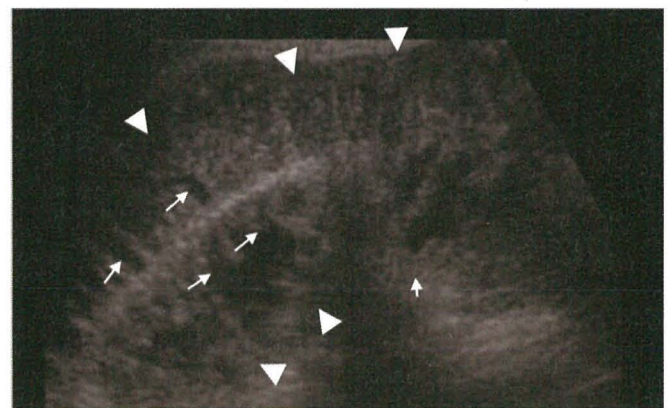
Ultrasound scan showing a thickened loop of small bowel (arrowheads) in the inguinal canal that did not alter with Valsalva manoeuvre and did not reduce on compression. Also note the thickened mucosal folds (arrows); the thickened bowel wall and bowel loops are indicative of hernia strangulation.
